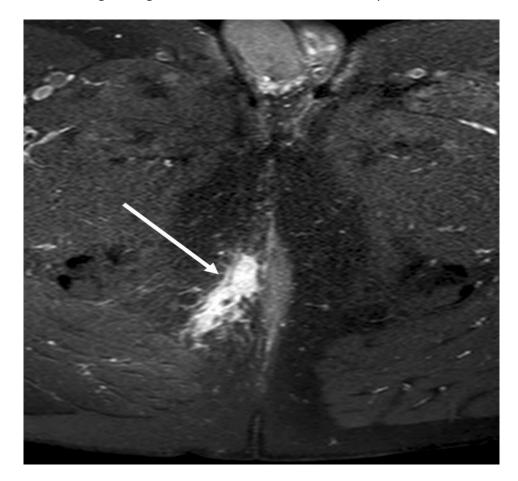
weighted image with fat-saturation after gadolinium contrast enhancement. Inflammation around a fistula is depicted by avid contrast enhancement (white arrow).
